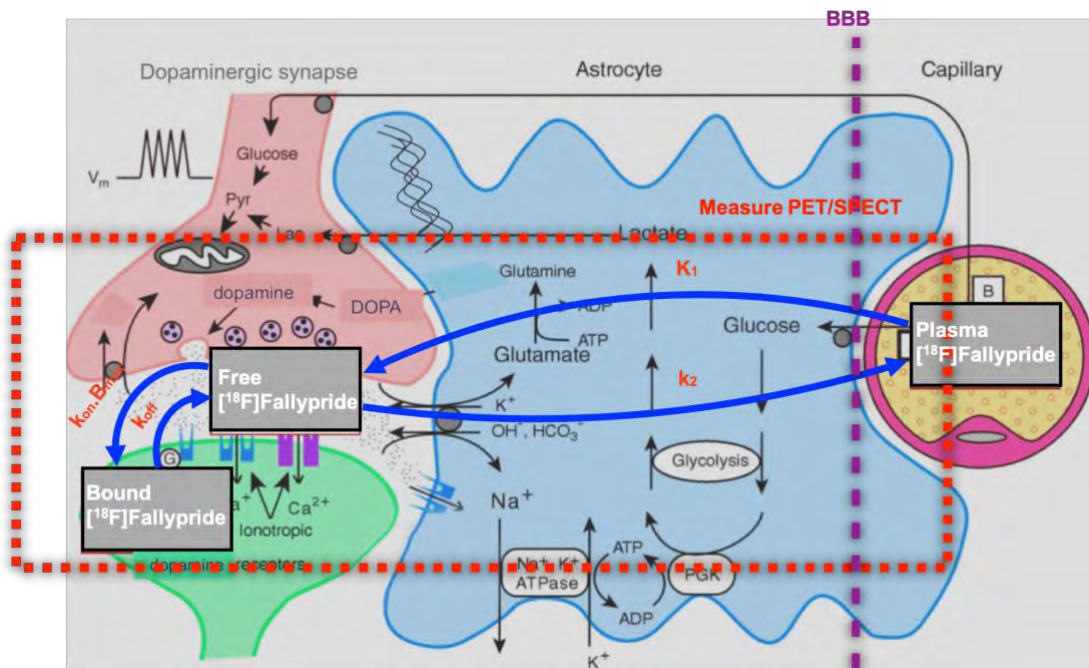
The PET or SPECT measure is an “average” measurement of the concentration of the radiotracer may be found in the brain, i.e. in the plasma of the brain vessels, in a “free” state in the tissue and bound to its receptor. Modified from Morris et al., 2014 and Pellerin et al., 1994. Courtesy of P. Millet.
